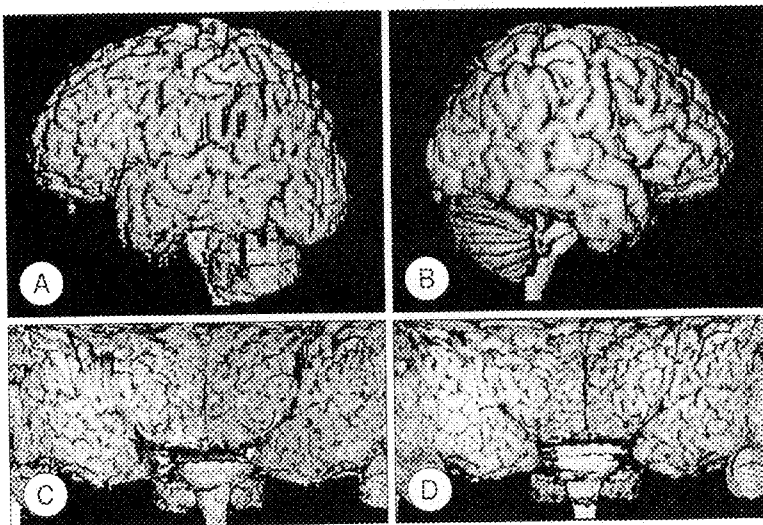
Upper row : 3D surface rendering of brain with different pulse sequences. A. Poor visualization of a brain surface with irregular gyral thickness and sulcal widths in fast SPGR MRI (TR/TE : 11.2/2, flip angle : 20°). B. More realistic cortical surface was generated in SPGR MRI (TR/TE : 30/7, flip angle : 45°). Lower row : Two different results of radial surface rendering of the same brain image of the fast SPGR MRI. Tight segmentation made brain cortex look like diffuse atrophy and loss of normal sulco-gyral patterns in left temporal lobe (C). However, the cortical image with an appropriate segmentation shows good sulco-gyral patterns (D).
